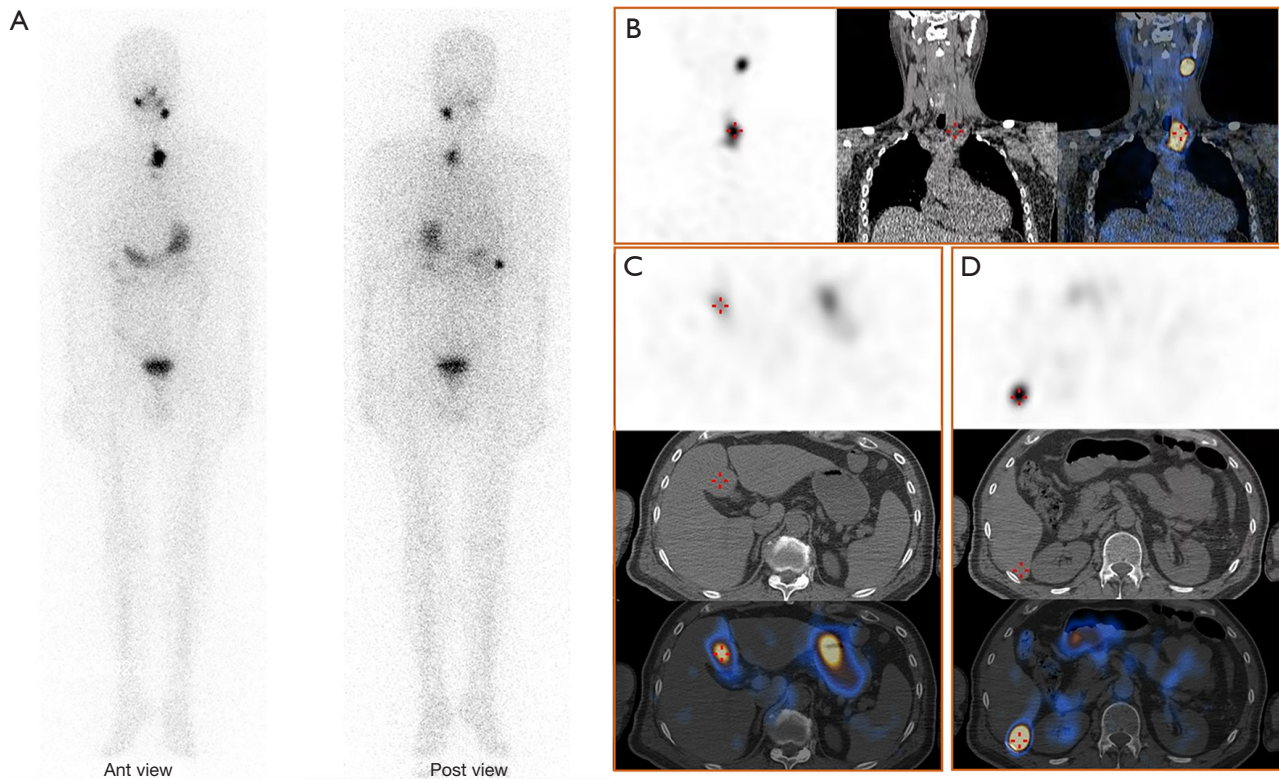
SPECT/CT images after the second RAIT. (A) Planar images of Rx-WBS; (B) fusion images of SPECT/CT in the left neck and upper mediastinum; (C,D) fusion images of SPECT/CT in the right lateral lobe of the liver. SPECT/CT, single-photon emission tomography/computed tomography; RAIT, radioactive iodine therapy; Rx-WBS, post-therapy whole body scan.
